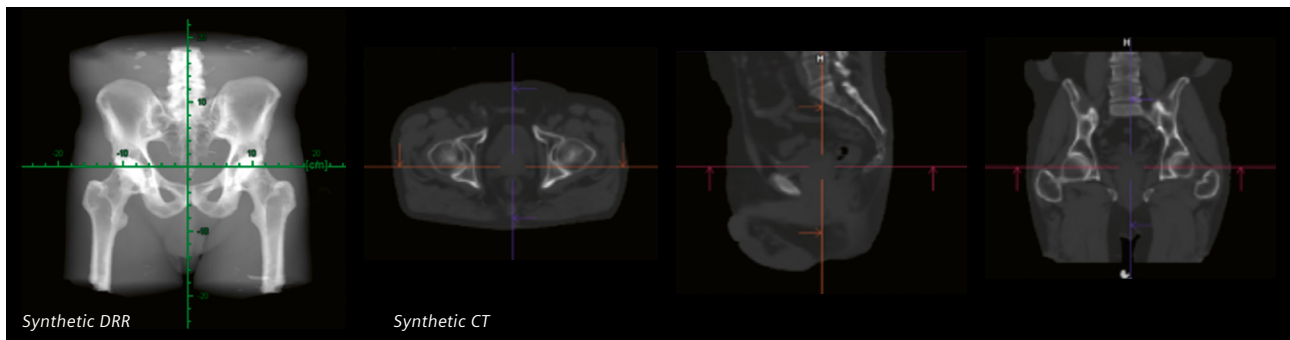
Synthetic DRR for matching with DRR and Synthetic CT for matching with cone-beam CT images for patient positioning.
